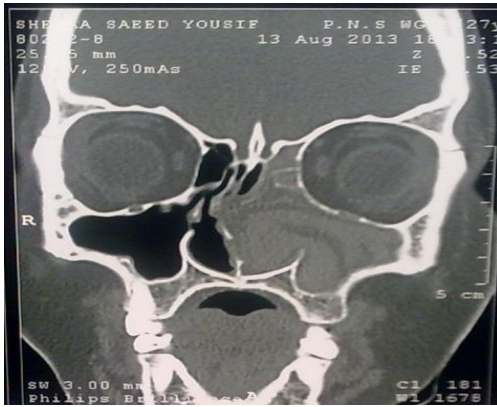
27 year's old female with history of asthma 13 year and left sided nasal obstruction & headache 5 year. Coronal CT scan shows heterogenous opacity of both left maxillary and ethmoidal sinuses, The high density of the opacifications (stars) are a typical finding in allergic fungal sinusitis (a case of recurrent allergic fungal sinusitis, patient with history of previous ESS twice). CT score =12 points
